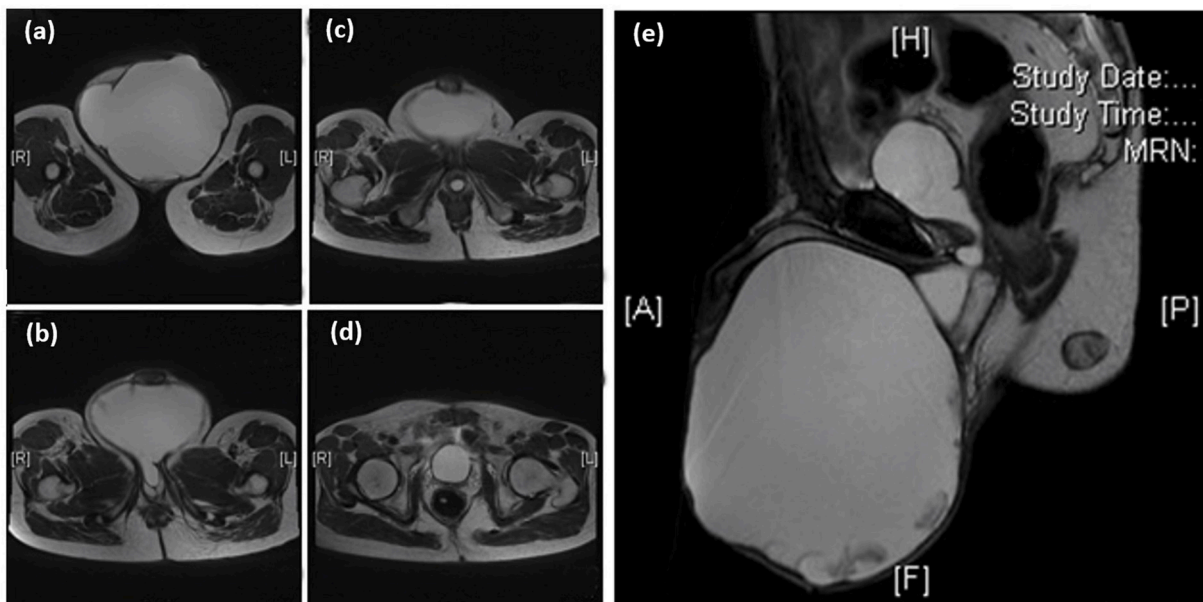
MRI T2 phase of scrotal and pelvis showing 13.5 × 16.8 × 17.5cm scrotal sac filled with fluid showing communication with the penile urethra at the root of penis, the prostate and seminal vesicles were not well seen. Transverse planes at: (a) lower scrotum; (b) & (c) level of the bulbous urethra; (d) base of the remnant bladder; (e) sagittal plane of pelvis and scrotum.
